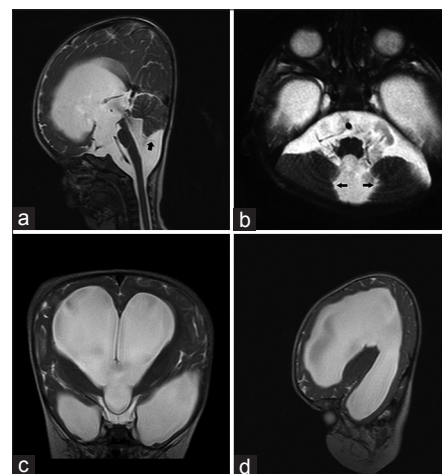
(a) Sagittal T2-weighted MR image demonstrating severe hydrocephalus with bulging third ventricular floor, open aqueduct and dilated fourth ventricle. Cerebellar vermis is compressed, relatively well-developed and is nonrotated. A thin line between dilated fourth ventricle and cisterna magna (Black arrow) indicates a Blake's pouch cyst. A high torcular Herophili with upward displacement of the tentorium is seen (b) Axial T2-weighted MR image with cystic dilatation of the fourth ventricle and compressed medial cerebellar hemispheres (Black arrows) (c) Coronal and (d) Sagittal T2-weighted MR images further demonstrate features of severe hydrocephalus
